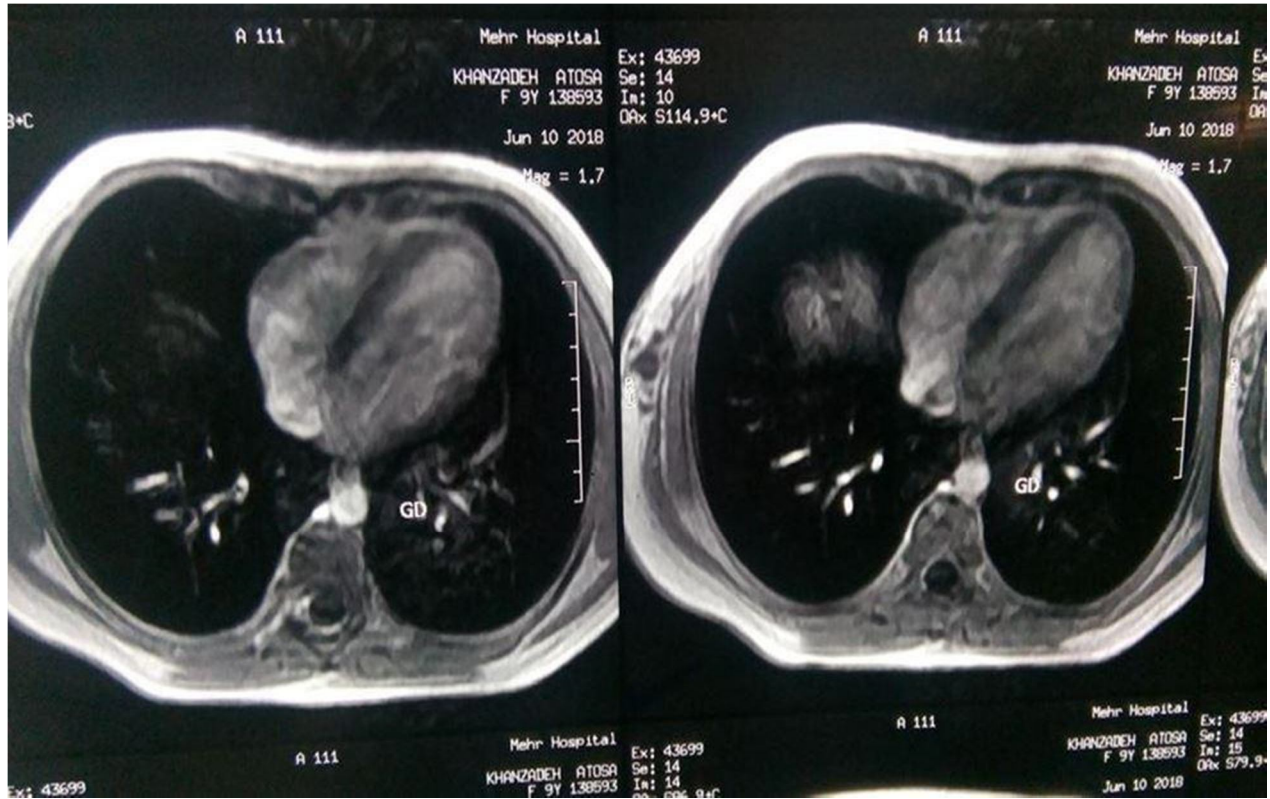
MRI of the chest. T1- weighted, with contrast and without fat suppression.
